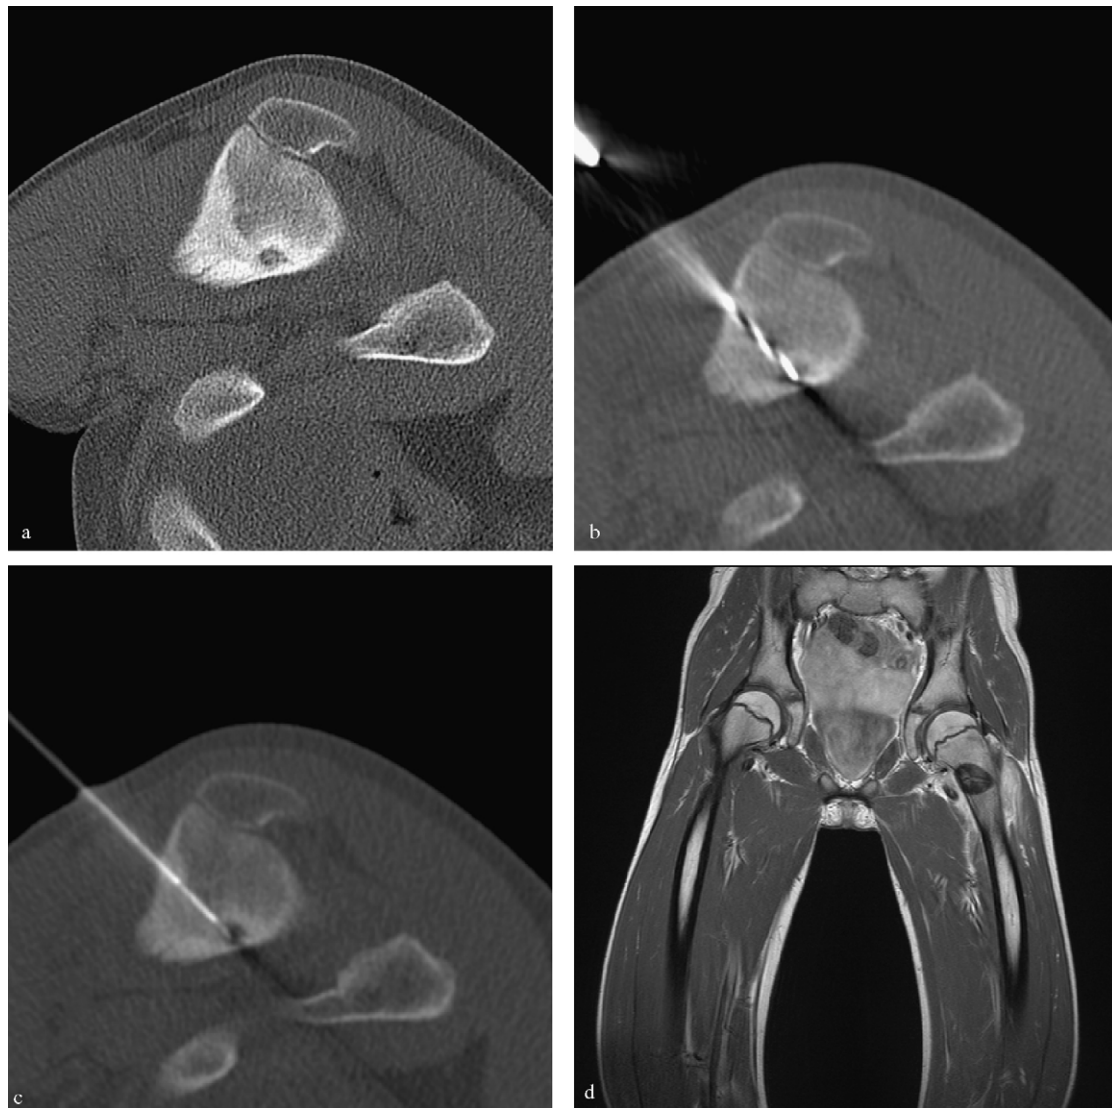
(a) 9 years old girl suffering from an OO of the femoral neck (minor trochanter). (b) The intervention was performed under general anaesthesia. First, an access path was created using a surgical drill. (c) After creating the access a RITA SDE electrode was inserted and the RF ablation was performed at a target temperature of 85 °C over a period of 8 min. (d) Patient had prolonged pain—therefore a MRI examination was performed 1 week after the initial treatment to rule out any severe complications. Extensive soft tissue edema was seen adjacent to the proximal femur. No signs of an abscess formation. The coagulation necrosis subsequent to RFA is depicted as an area of low signal intensity.
